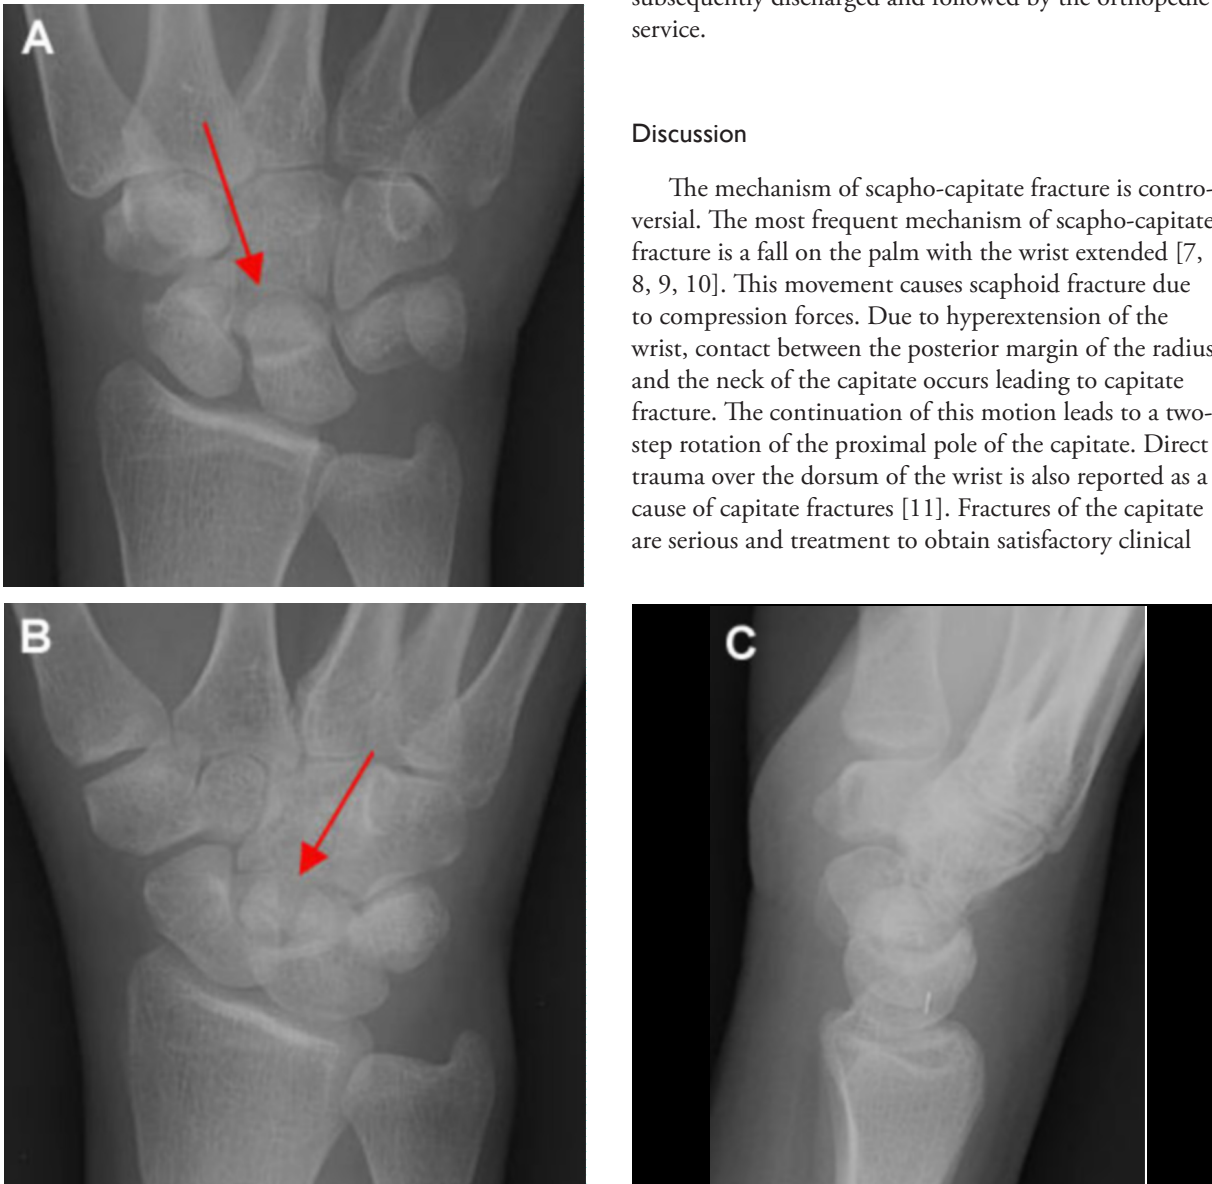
Frontal (A) and oblique (B) right wrist radiographs demonstrate a fracture of the capitate (arrows) with no other injuries identified. On the lateral radiograph (C), the capitate fracture fragment is hard to discern.
